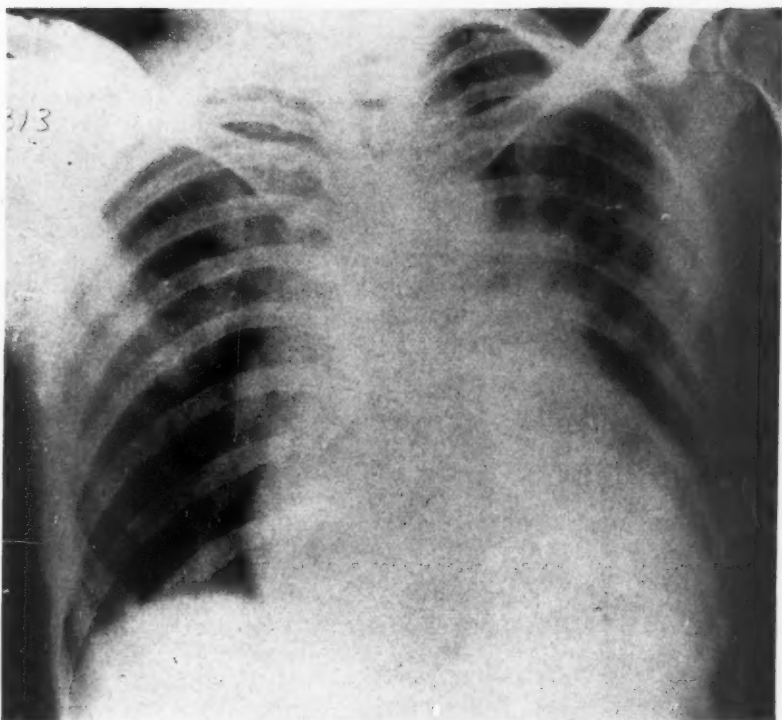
Roentgenogram of chest taken Feb. 24, 1943, showing little change from that of Aug. 28, 1943, except for slight increase in size. The prominence of the right border is still present.
